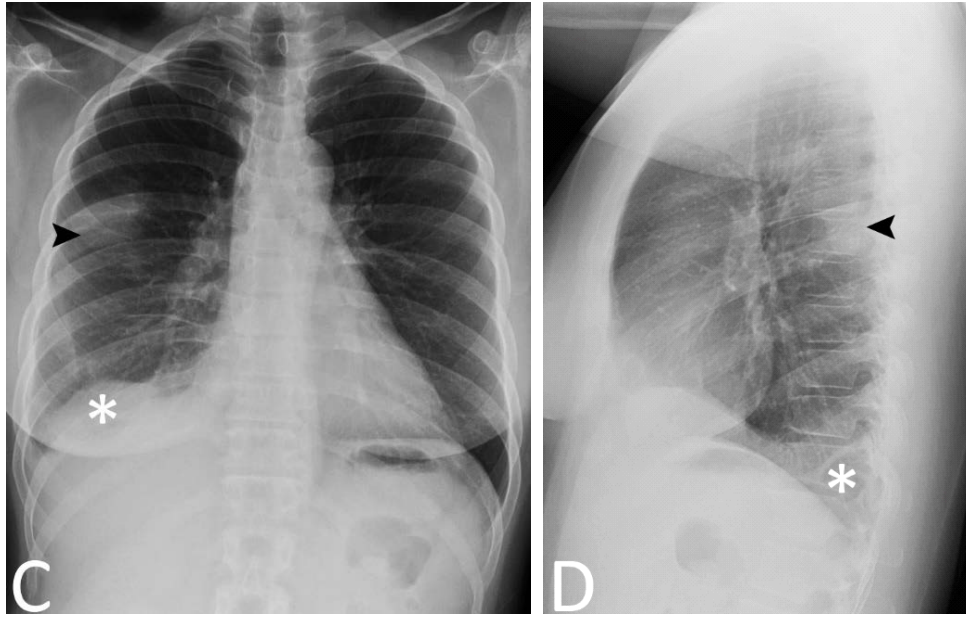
Figure C,D: Frontal and lateral chest radiographs at the time of presentation to our institution demonstrate a lentiform density (asterisks) at the right posterior costophrenic angle creating the so-called spine sign on the lateral view (6). There is also a small amount of pleural fluid in the major fissure posterosuperiorly (arrowheads).
